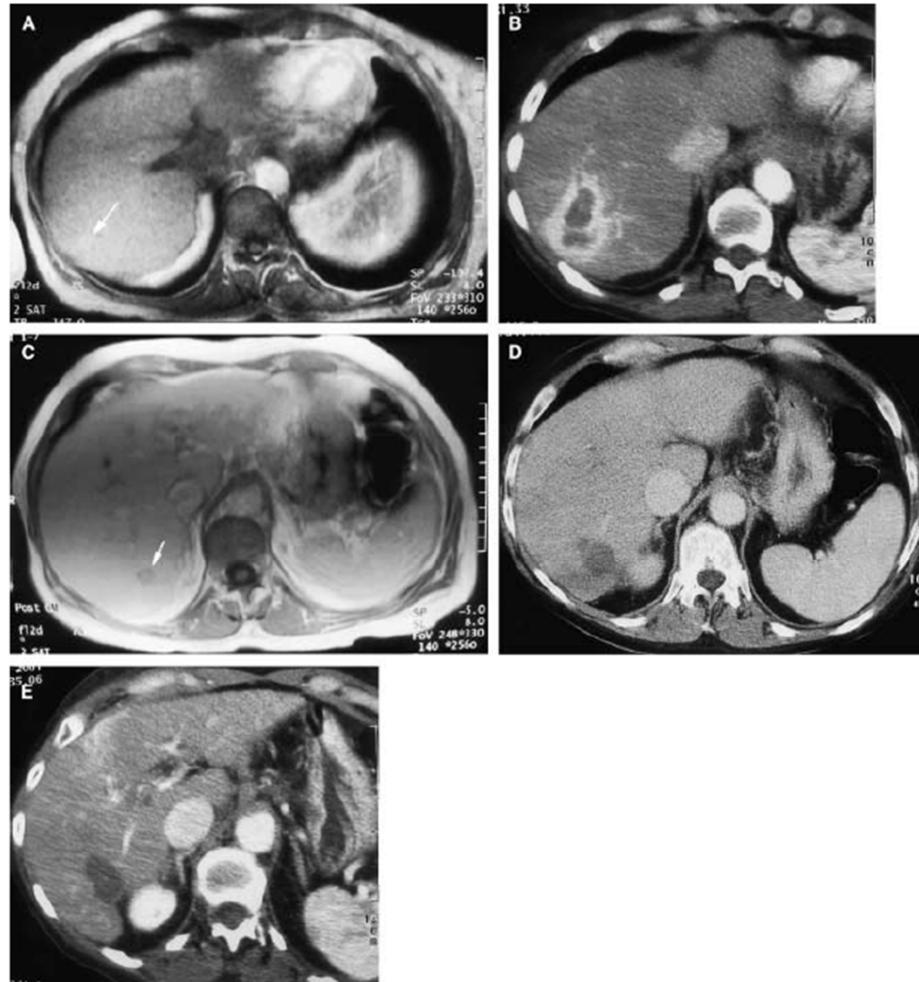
Imaging studies of patient 1. (A) Magnetic resonance image, showing an enhancing 0.9-cm lesion in segment 7 (arrow – lesion 2). (B) Computer tomography scan, showing lesion in Fig. 1A immediately after ablation. Note the larger size of the lesion, as compared with the initial observed lesion (Fig. 1A). (C) Magnetic resonance image of the first lesion before ablation (arrow). (D) Computer tomography scan of the first treated lesion, taken 4 months after ablation of the first lesion. (E) Computer tomography scan of the first treated lesion, taken 8 months after ablation of the first lesion. This first lesion remained stable in size and does not demonstrate areas of enhancement.
